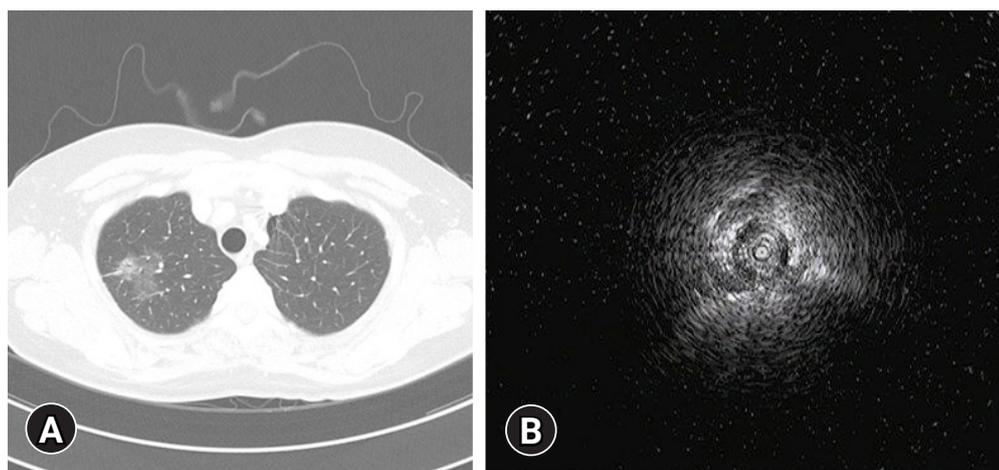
Axial image of chest computed tomography (A) and the ultrasound image (B) associated with radial probe-endobronchial ultrasound-guide sheath performed to diagnose ground-glass opacity pulmonary lesions.
